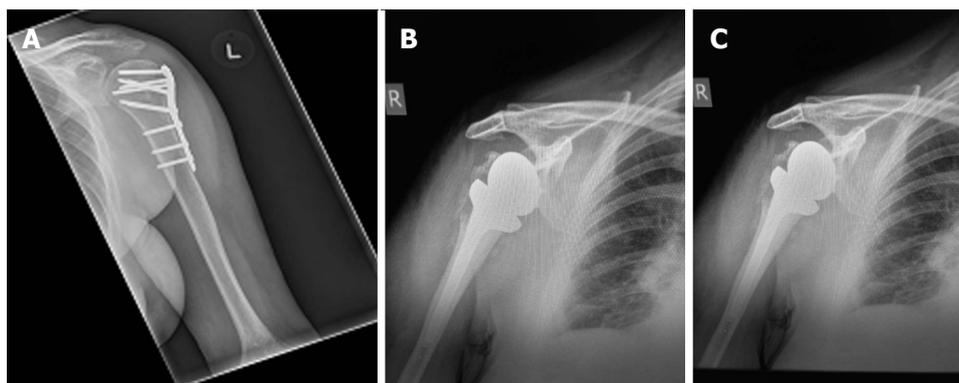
Plain radiograph. A: Showing internal fixation of a left proximal humerus fracture with a locking plate; B: Showing a cemented right shoulder hemiarthroplasty; C: Showing a reverse polarity right total shoulder arthroplasty.
